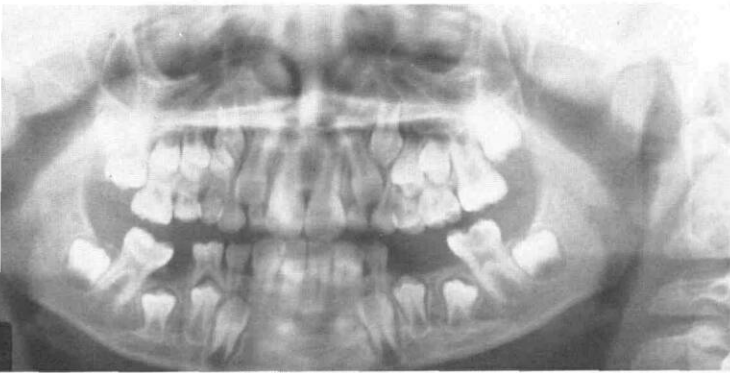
A panoramic radiograph showing maxillary right first supernumerary primary molar and supernumerary permanent premolar.
